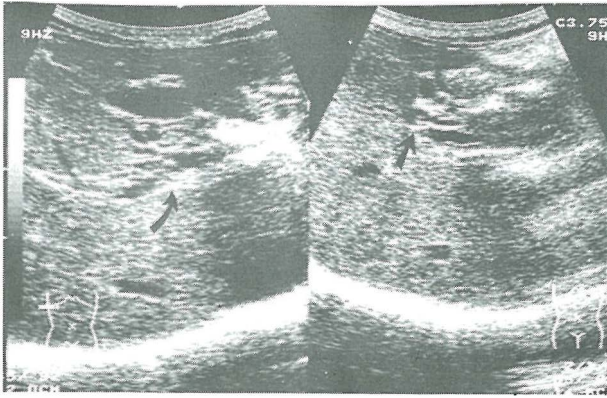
Ultrasonography, a transverse sonogram, level of porta hepatis, shows echogenic band (arrows) resulting from fibrosis of portal vein branches and tubular structures replacing the main portal vein.
